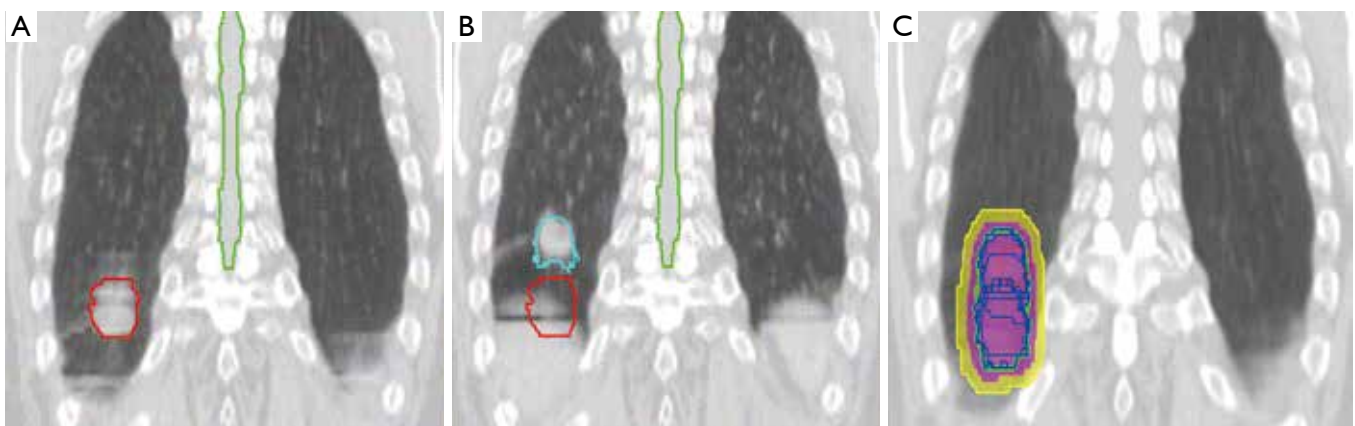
4DCT images of an early-stage lung cancer patient at end-inhalation (A); end exhalation (B); and contours from all 10 phases of the 4DCT combined (C). Abbreviation: 4DCT, four-dimensional computed tomography.
